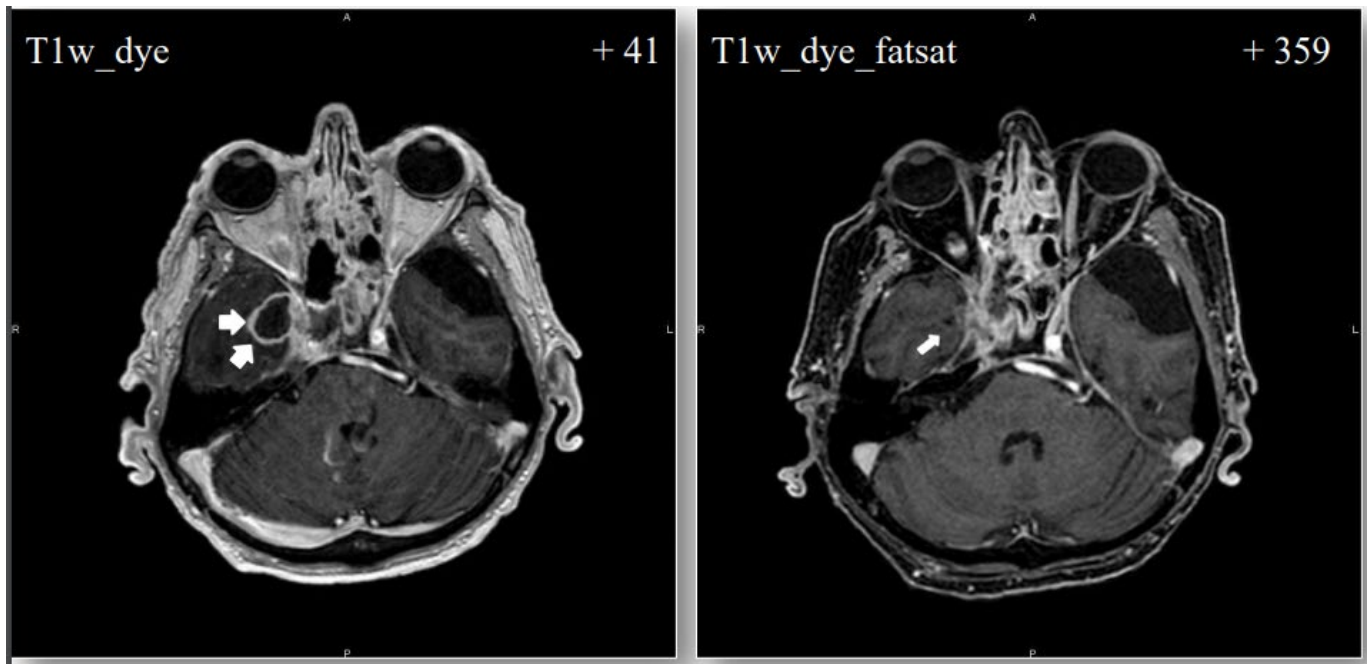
MRI images showing endocranial mycotic abscess at day 41 and the result at the end of treatment with ISC, day 359.
